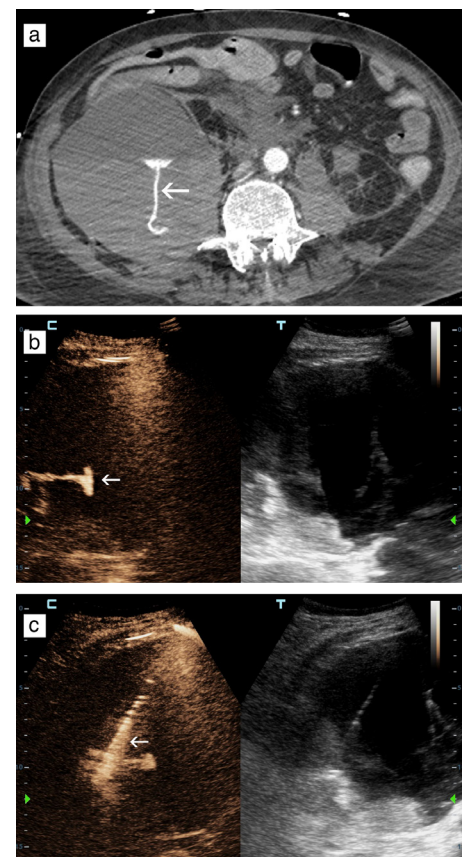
(a–c) Case 1. Axial section of contrast-enhanced CT (arterial phase) pre-intervention: (a) shows the large right retroperitoneal hematoma and one of the sites of extravasation (arrow). Sonographic “dual screen” image (unenhanced, reference, gray-scale image on the right; CEUS image on the left) immediately post-transarterial embolization; (b) shows a persistent jet of active extravasation (arrow); a close correlation with the CT image is noted. Sonographic image (same configuration as previous image) during PTI; (c) shows the Chiba needle, which has reached the proximal part of extravasation, and thrombin injection as linear and punctate echogenicities (arrow). CT, computed tomography; CEUS, contrast-enhanced ultrasound; PTI, percutaneous thrombin injection.
